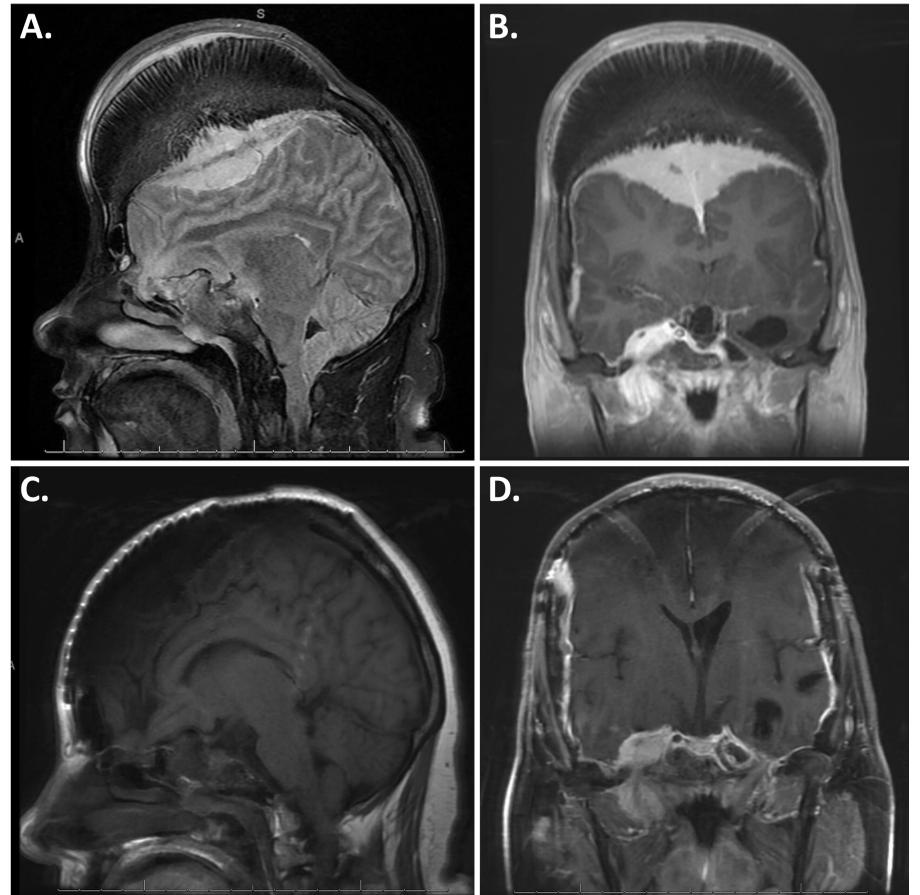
a) Pre-operative sagittal T2 FLAIR FS MRI with/without contrast b) Pre-operative coronal multiplanar reconstruction MRI with/without contrast c) Six-month follow-up sagittal T1 FLAIR MRI with/without contrast d) Six-month follow-up coronal T1 FLAIR MRI with/without contrast
